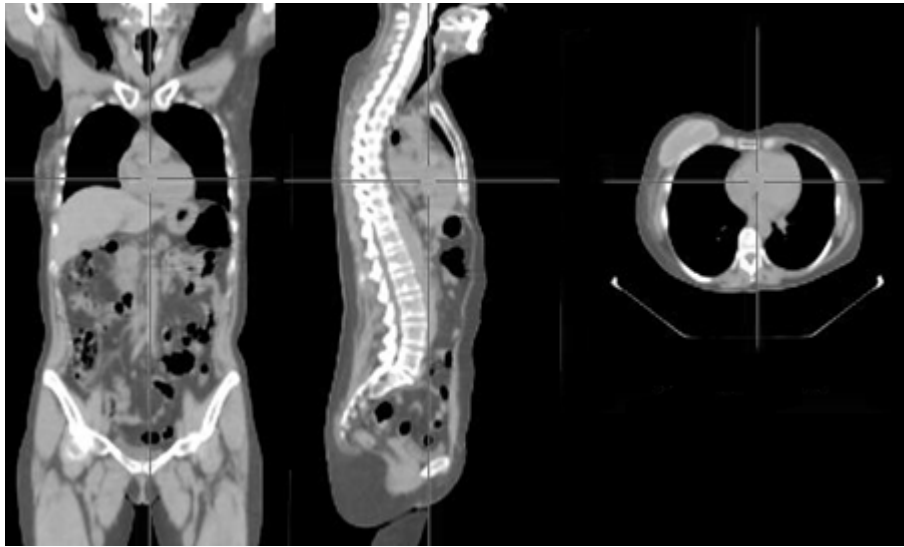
An example of CT acquisition (coronal, sagittal, and axial imaging planes).
